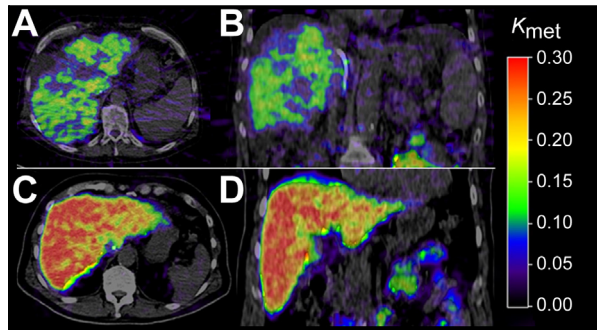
Examples of parametric images of the hepatic systemic clearance of FDGal (K_{met} , mL blood/mL tissue/min) generated from dynamic FDGal PET/CT recordings. Top row is from a cirrhotic patient (panels A and B) and bottom row is from a healthy subject (panels C and D). Left images are transaxial, right images coronal. The patient is a 57-year-old male with cirrhosis (alcohol and hepatitis C virus), a global liver function of 45% of expected value as measured by a galactose elimination capacity (GEC) test, and portal hypertension (HVPG, 30.5 mmHg).
